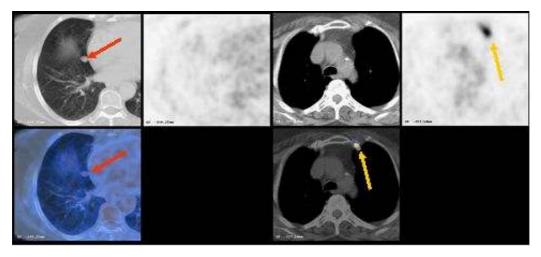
Breast cancer suspected of recurrence. CT identifies a possible metastasis in the right lung (yellow arrows) that does not show any FDG (see para. 20) uptake in PET imaging. PET, on the other hand, identifies an unknown metastasis on the contra-lateral side (red arrows).
